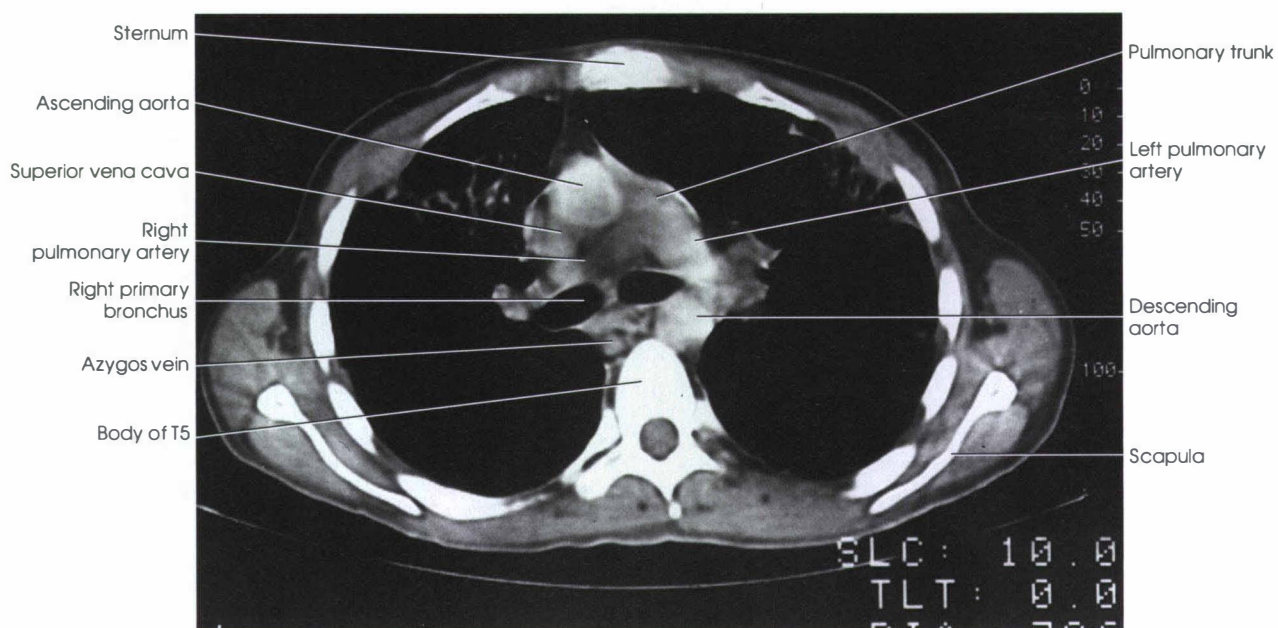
CT image corresponding to Fig. 27-21.
